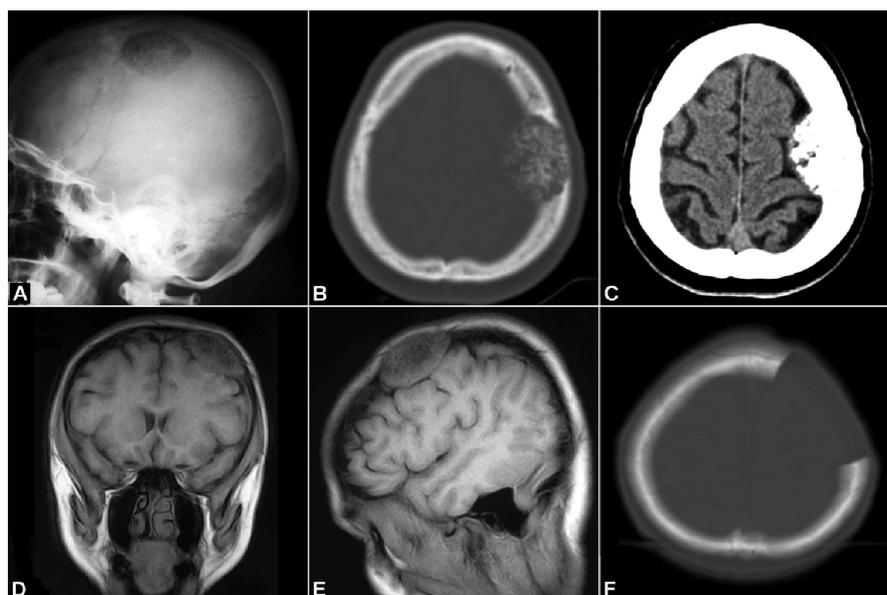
Lateral X-ray of the skull (A), CT of the head with bone window (B), and cerebral window (C) show large inhomogeneous lesion of honeycomb appearance in the anterior part of the left parietal bone with intracranial extension. MR postcontrast T1-weighted images in the coronal (D) and sagittal (E) planes provide good visualization of the compression of the brain by the bone lesion, slightly enhanced after contrast medium injection. Follow-up CT scan with bone window (F) shows postoperative bone defect with no hematoma visible and no compression of the brain.
